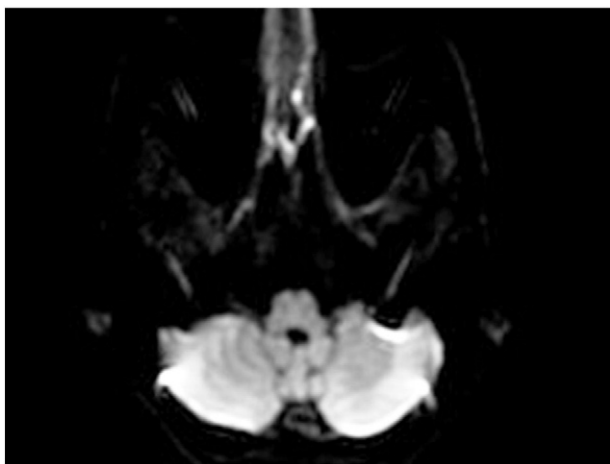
MRI brain image. Axial MRI of the brain (including diffusion weighted imaging) through the posterior fossa and posterior cerebral artery distribution territory reveals no evidence of acute or subacute infarction. (Color version of figure appears online.)
